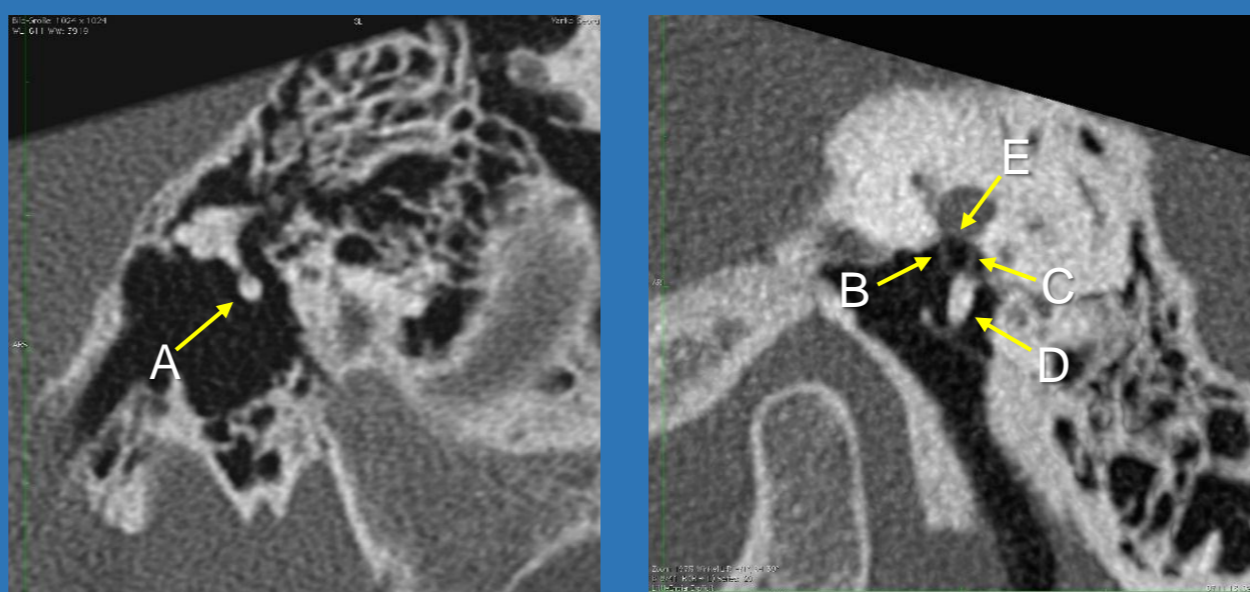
Follow-up CT scan 2 months after the surgery. A - *articulatio incudostapedialis*, B - *crus anterior stapedis*, C - *crus posterior stapedis*, D - hydroxyapatite bone cement, E - *foramen ovale*.
